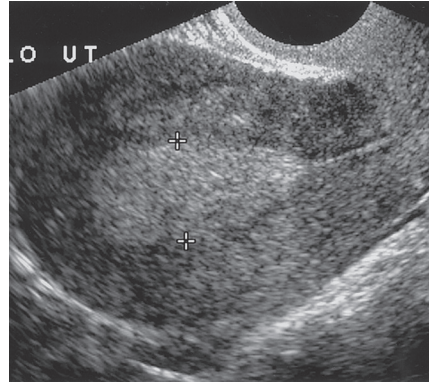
Normal reproductive age endometrium. Sagittal ultrasound image of the uterus obtained during the secretory phase of the menstrual cycle shows a thickened, echogenic endometrium (cursors).
